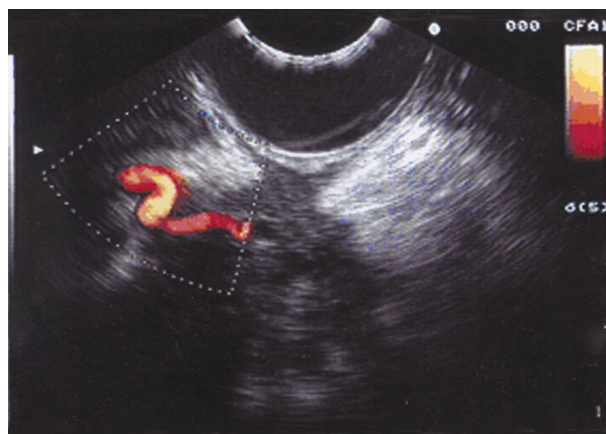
Pancreatic cancer – EUS + Doppler technique – no signs of vessel infiltration
